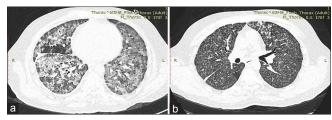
(a) High-resolution computed tomography thorax at the time of admission showing extensive bilateral ground glass opacities (b) High-resolution computed tomography thorax after 1 week of steroid treatment shows bilateral nodular opacities and tree in bud in the left lung parenchyma
